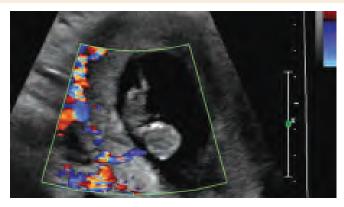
Transvaginal power Doppler scan of a missed abortion at 8 weeks' gestation. The flow pattern reveals blood flow within the maternal vessels and absence of the flow in fetal vessels. Ultrasound findings should always be correlated with the patient's symptoms, gestational age, and β -hCG values
